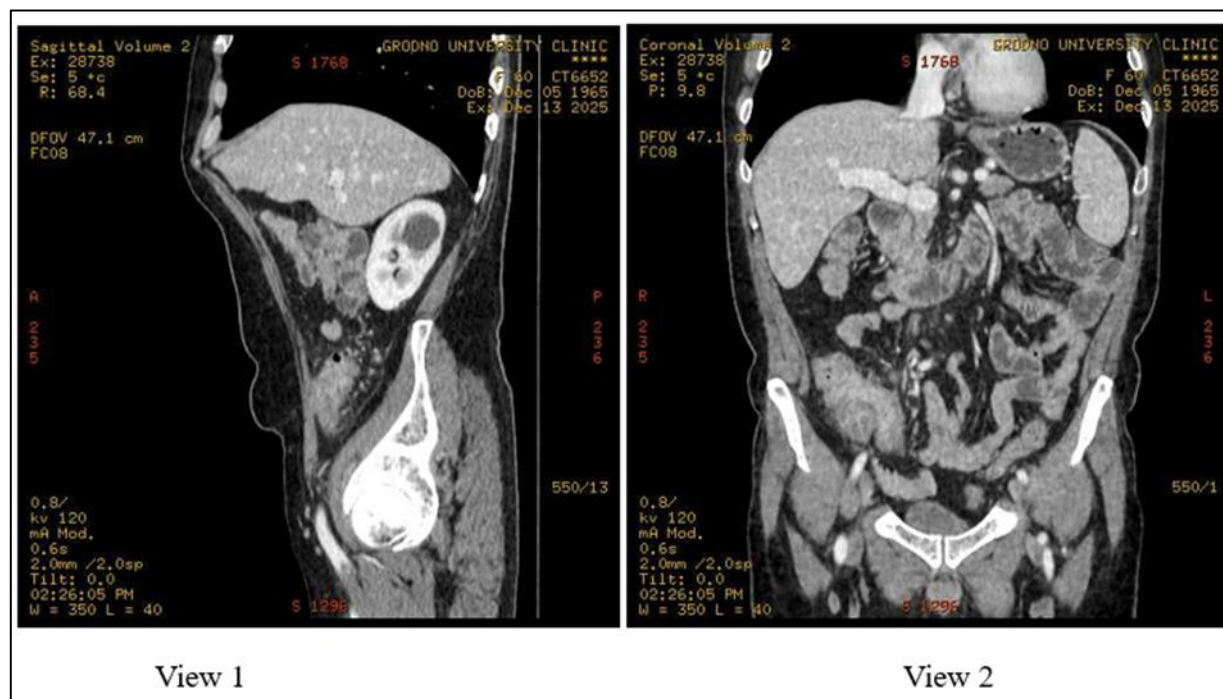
Sagittal (view 1) and coronal (view 2) contrast-enhanced CT reconstructions demonstrate asymmetric circular thickening of the cecal wall up to 27 mm, a 3.1 cm necrotic paracolic lymph node conglomerate, and multiple hepatic metastases alongside a suspicious lytic lesion in the L4 vertebral body. The images also highlight significant renal findings, including a well-defined 3.5 cm hypodense cyst in the upper pole of the right kidney.
